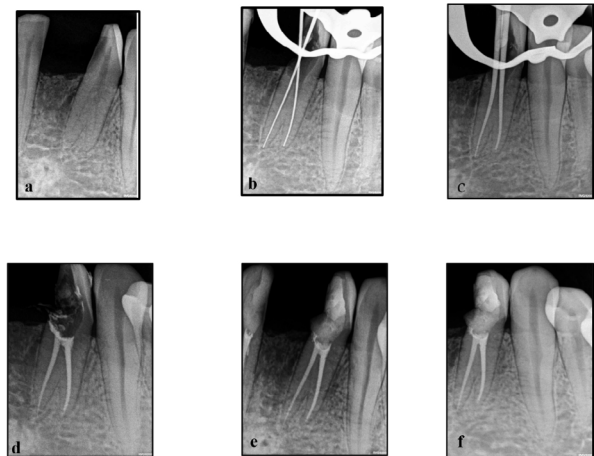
Radiographic records: preoperative radiograph (a), working length determination (b), master cone (c), post obturation (d), post endodontic restoration (e), follow up (f)
